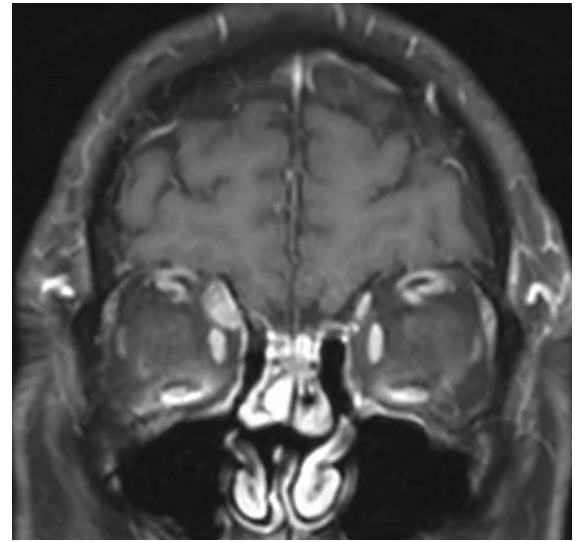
T1 post-contrast coronal MRI of the orbits. There is a $0.7 \times 1.4 \times 1.9$ cm mass in the right orbit indistinguishable from the superior oblique muscle. This is isointense to skeletal muscle on T1 imaging and homogeneously enhancing after intravenous contrast
